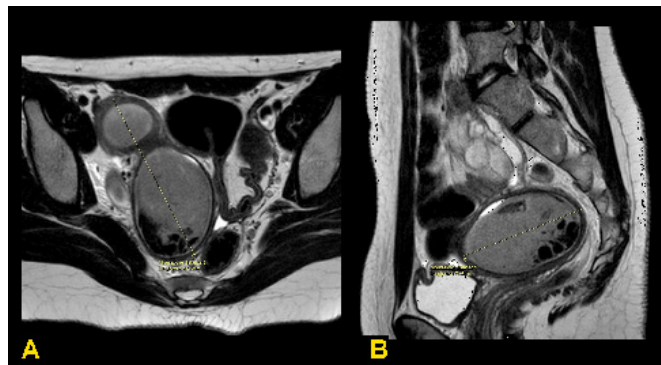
Abdominal MRI scan showing a pelvic mass reported to an endometrioma; A: transverse section B: sagittal section.
